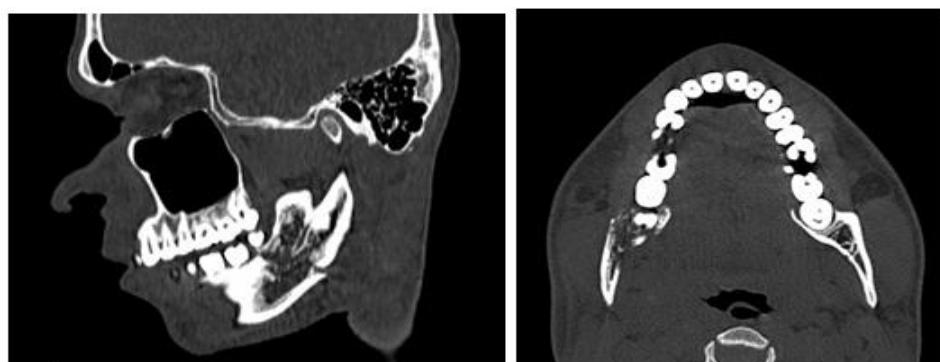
Preoperative CT- Scans in the sagittal and axial planes denoting the angle fracture
